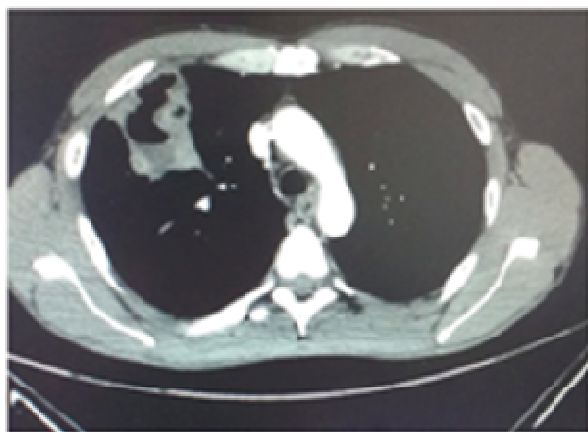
CT chest scan: Abscessed pneumonia in upper right lobe
